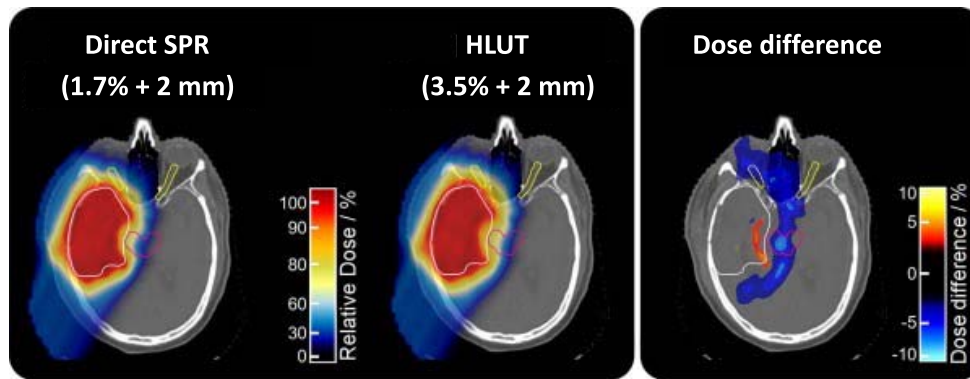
Clinical treatment plan of a representative glioblastoma patient calculated using the DirectSPR method with the reduced range uncertainty margin (1.7% + 2 mm) thanks to dual energy CT (left) in comparison to the conventional method using hounsfield look-up tables (HLUTs) with the old clinical margin (3.5% + 2 mm) (middle). The prescribed dose to the target was 60 Gy. From [158], used under the creative commons CC-BY-NC-ND license.
